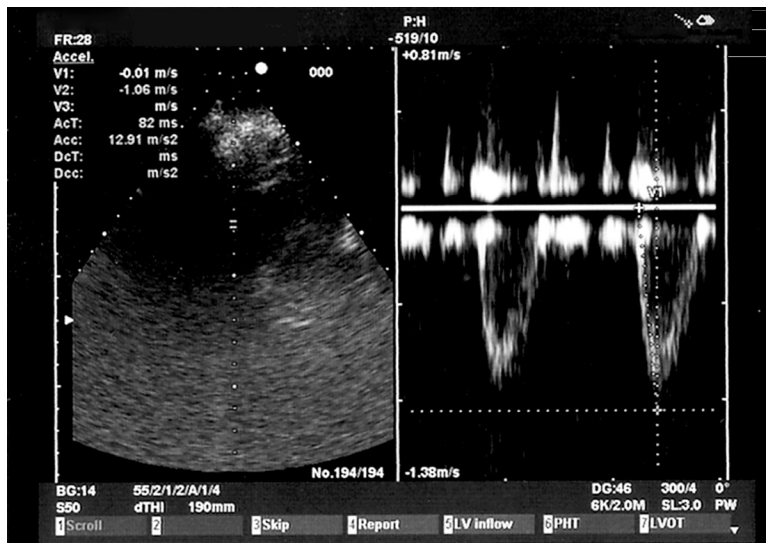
Doppler estimation of systolic pulmonary artery pressure using two-dimensional echocardiography; acceleration time of 82 ms equates to a systolic PAP of around 45 mmHg.
